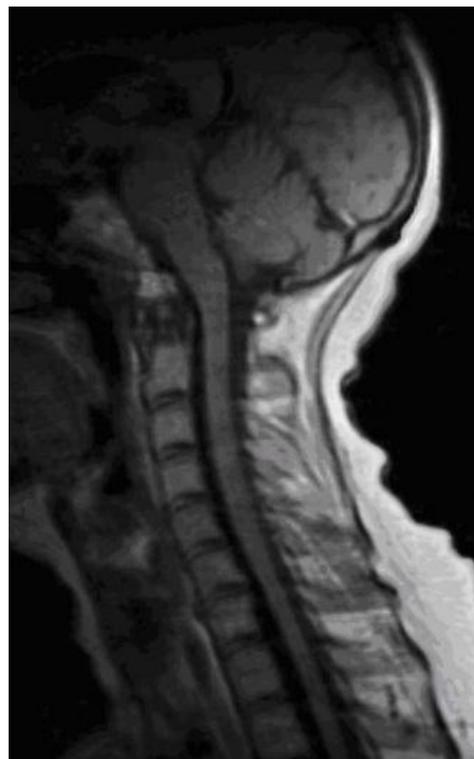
Cervical spine MRI: stage 1 degenerative disc disease at C3–C6, small disc osteophyte complex at C5–C6. No pathological foci detected
